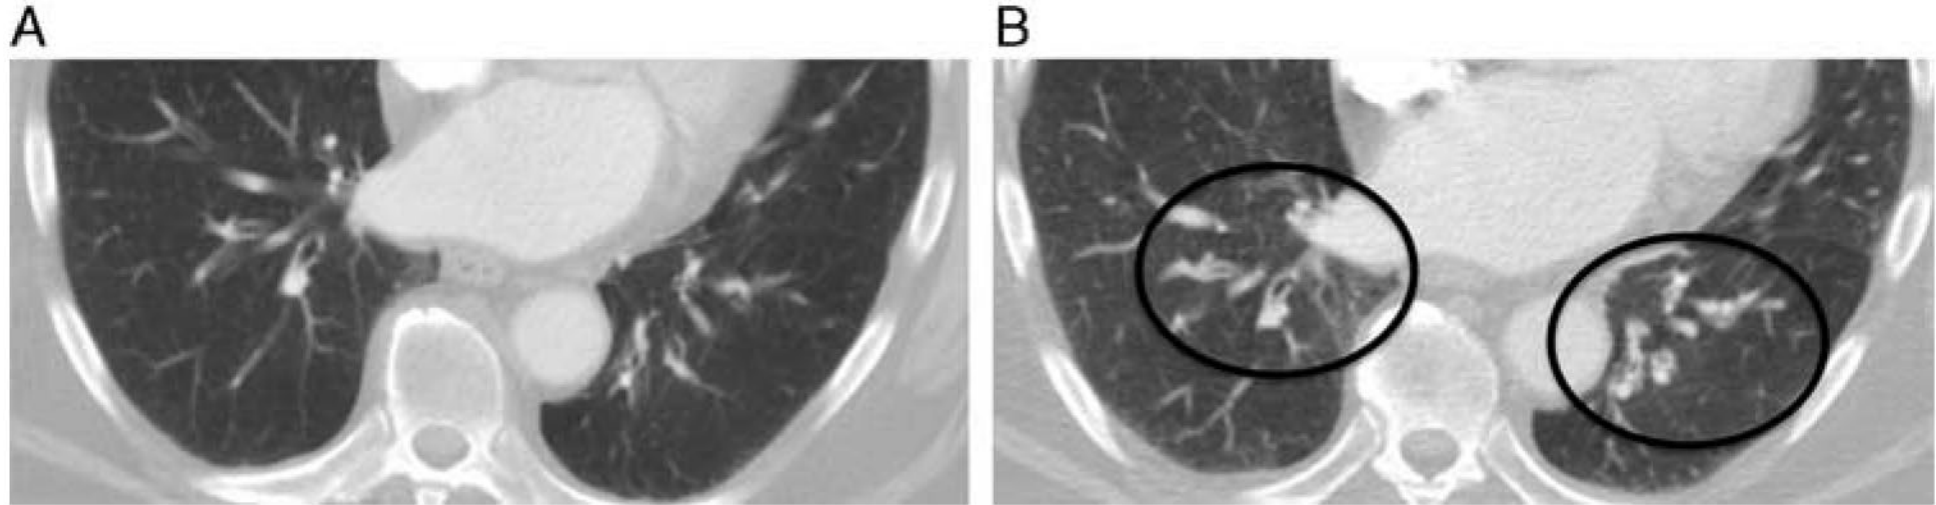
A and B, Aspiration bronchitis after LAGB. A 60-year-old woman with a history of LAGB and development of increasing dyspnea and chest pain 2 years after surgery. Baseline scan (A) demonstrates no significant abnormality. Repeat CT scan (B) shows development of new mild peribronchial thickening in the lower lobes (circles).
